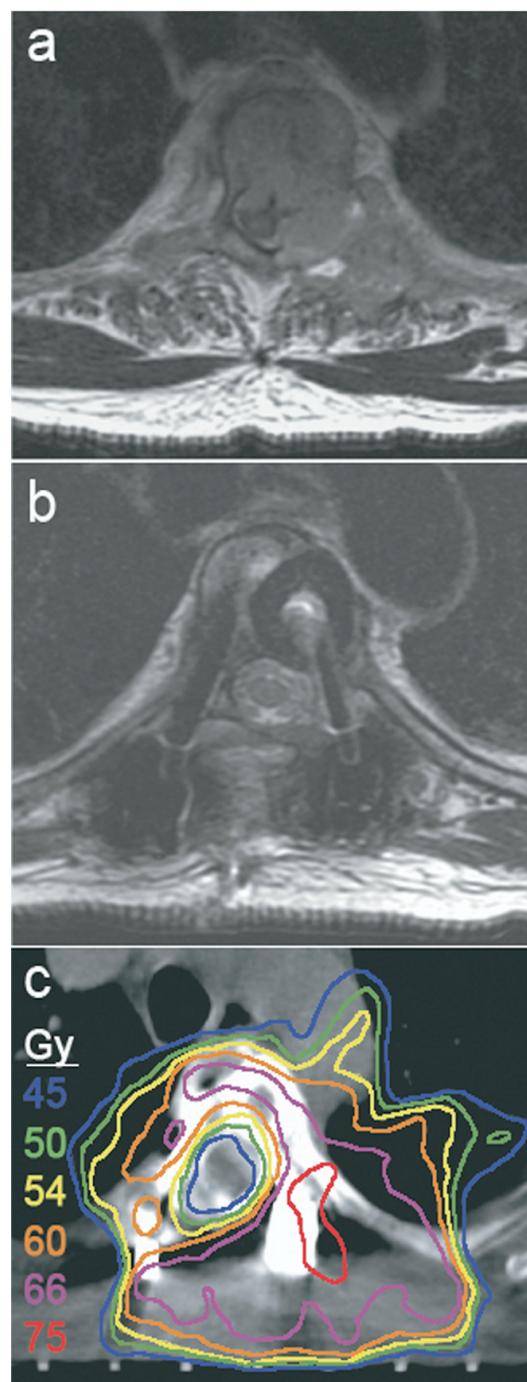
(a) Preoperative axial T2 fat spin-echo magnetic resonance image (MRI) of T3 high-grade sarcoma. (b) Postoperative axial pure T2 MRI with hardware artifact. (c) Intensity-modulated radiotherapy (IMRT) plan.
